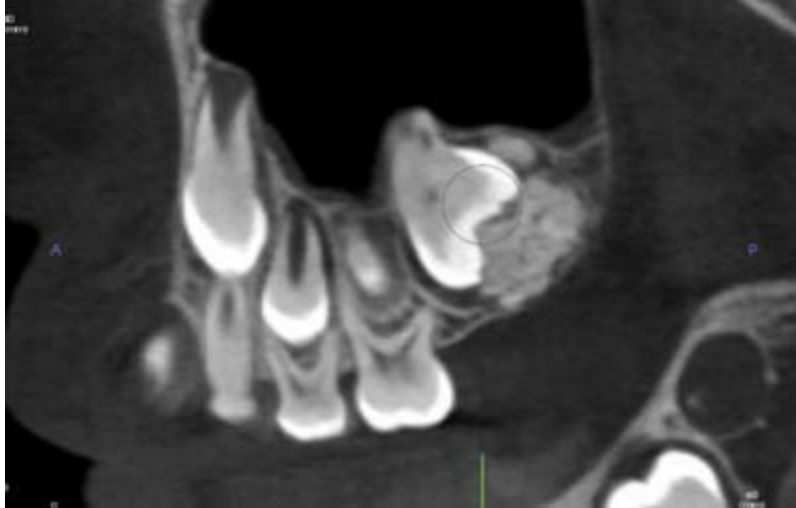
Complex odontoma. Sagittal CBCT image with a high-density globular mass near the crown of a maxillary first molar. The mass exhibits the density of dentin.
